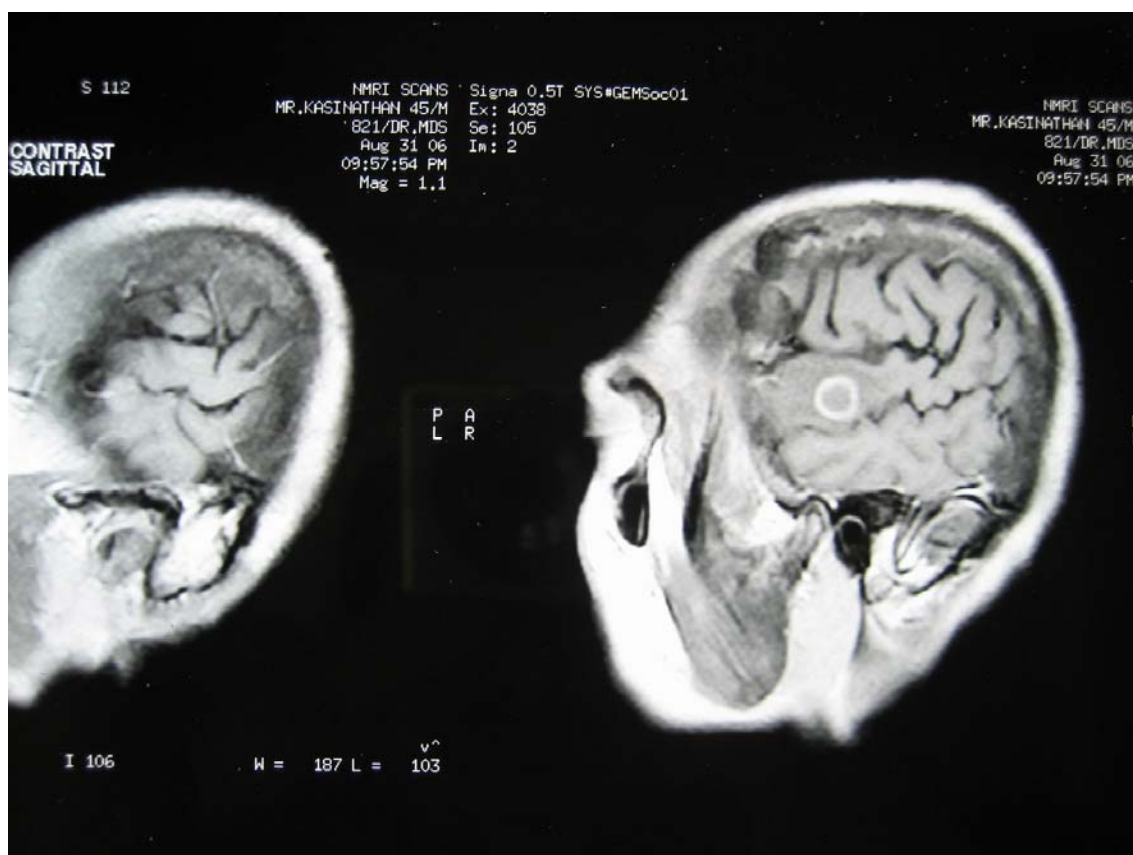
MRI Brain showing ring enhancing lesions (Tuberculoma)
